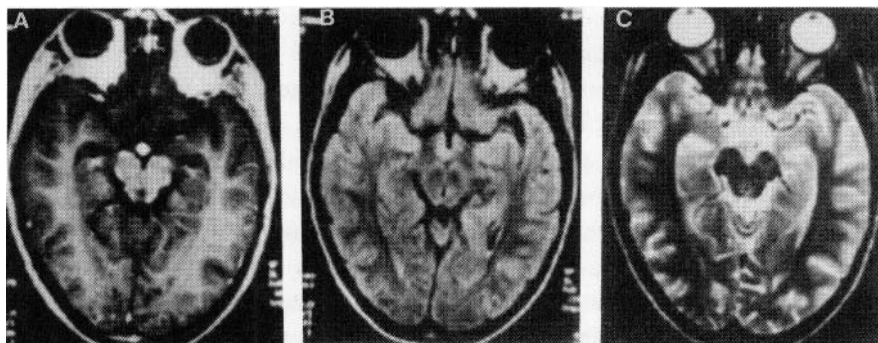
Images obtained using gradient echo technique of a normal subject. T1-weighted image (a) obtained using TE/TR/flip angle of 5 ms/200 ms/45°. Proton density image (b) obtained with TE/TR/flip angle of 5 ms/200 ms/10°. T2-weighted image (c) obtained using TE/TR/flip angle of 15 ms/200 ms/15° yielding T2-weighted image. Note that the signal-to-noise ratio of the images is proportional to the flip angle, and that the contrast depends quite critically on the combination of these three different sequence parameters.
